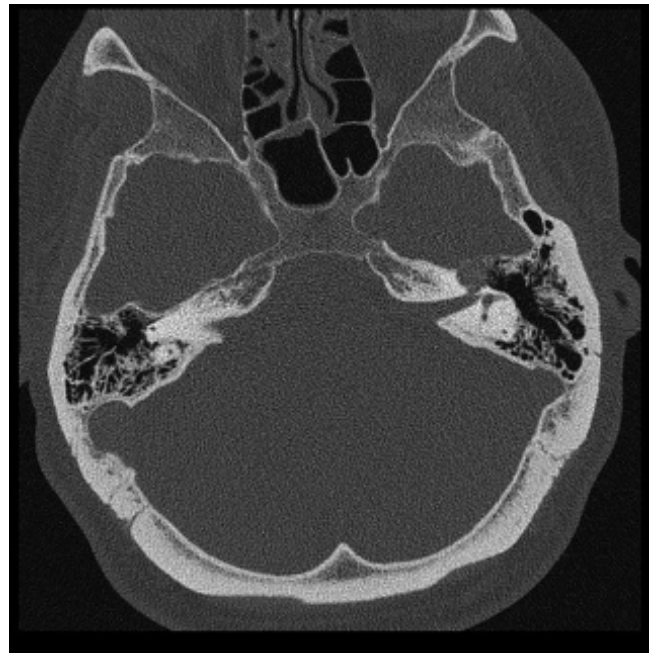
Axial CT of temporal bones at the level of the IAM/geniculate ganglion on the left with a round smooth bony expansion of the geniculate fossa caused by a facial schwannoma. (See [Figure 113.5](#) for corresponding MRI.)
